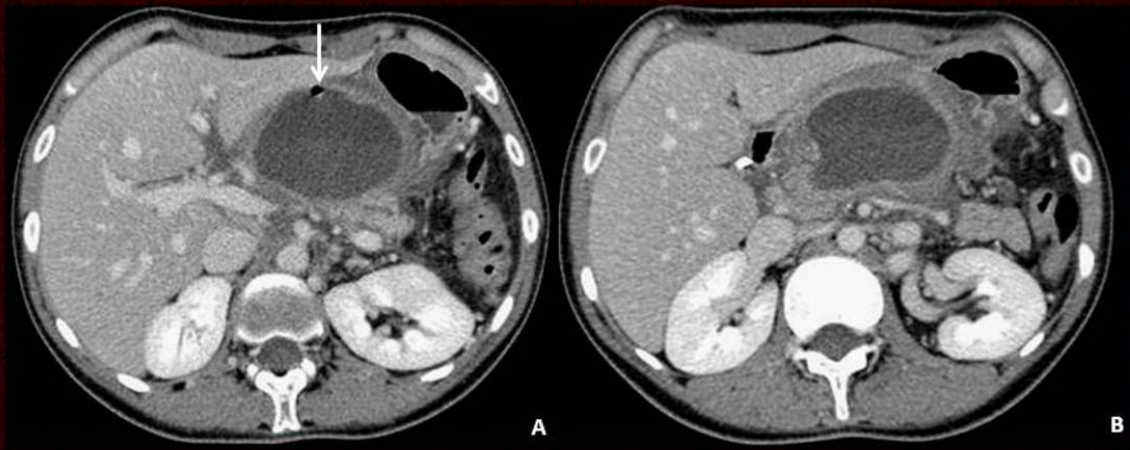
Organized pancreatic necrosis in a 30-year-old woman with fever and abdominal pain. Contrast-enhanced CT scan shows a large fluid collection replacing the parenchyma of the pancreatic body. An air bubble is seen (arrow in A), suggesting superinfection.
